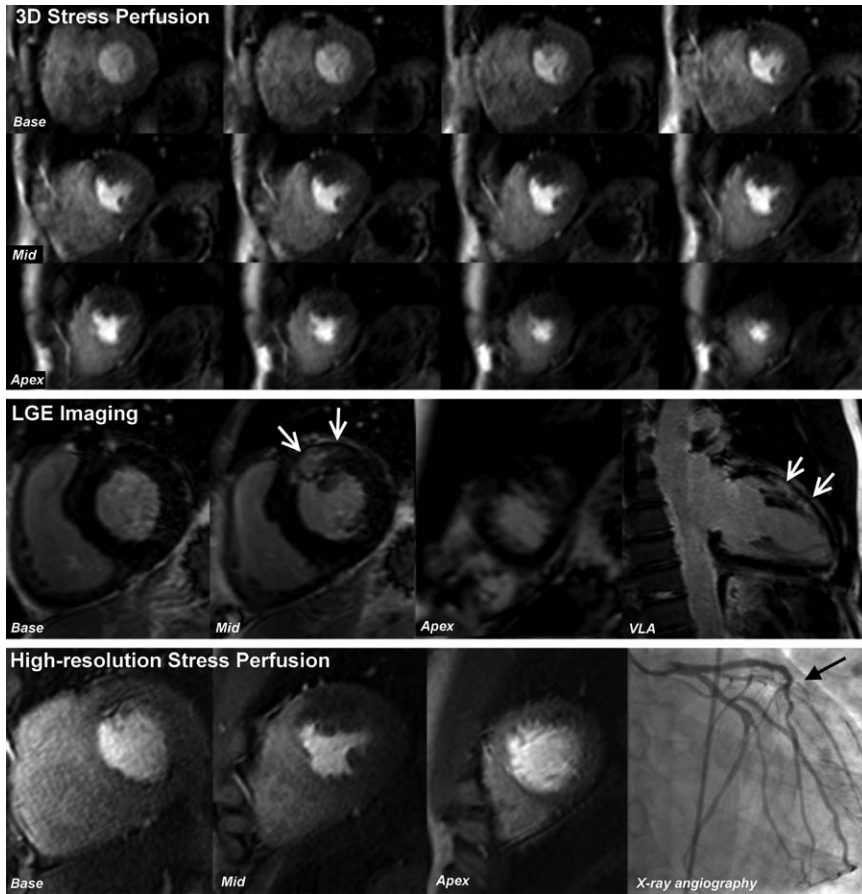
Case example 2. A 45-year-old man with previous PCI to the LAD represented with significant angina. The top panel dimensional shows 3-dimensional (3D) perfusion cardiovascular magnetic resonance (CMR; 12 slices) at stress; the middle panel shows late-gadolinium enhancement (LGE) imaging; and the bottom panel shows high-resolution (1.1 mm in-plane) stress perfusion CMR, all performed at 3.0 T. 3D perfusion CMR shows stress-induced hypoperfusion throughout the anterior wall from base to apex, that is, well beyond the area of scar seen in the mid-anterior wall on LGE imaging. This example shows the benefit of whole-heart coverage with the 3D acquisition, because the 3-slice high-resolution techniques did not demonstrate any significant ischemia beyond the established scar in the mid-ventricle. X-ray angiography confirmed a subtotal occlusion of a large diagonal branch, accounting for the anterior ischemia (black arrow). LAD indicates left anterior descending artery; PCI, percutaneous coronary intervention; and VLA, vertical long axis.
